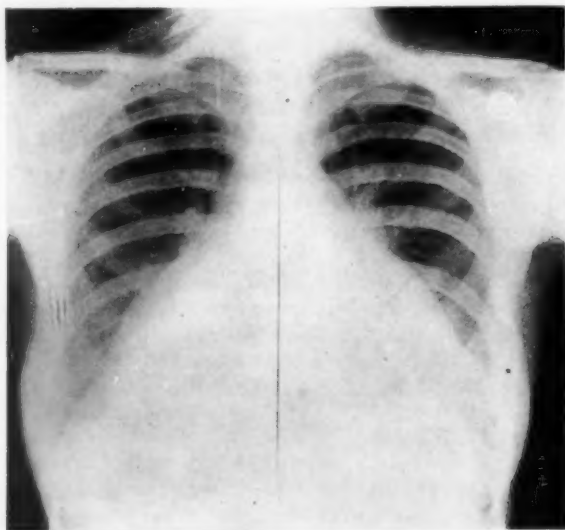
Roentgenogram of heart in case 1.
